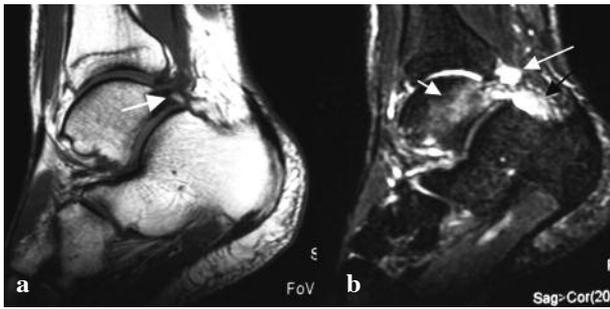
MRI Posterior Ankle Impingement – (a) Sagittal T1-weighted image showing the typical position of Os trigonum, an anatomical variant that may predispose to the posterior ankle impingement. (b) Sagittal STIR image depicting the typical findings of PAIS including oedematous os trigonum (long white arrow), marrow oedema in the talus (short white arrow) and increased signal within thickened soft tissues indicating posterior synovitis at the posterior aspect of the subtalar joint.
